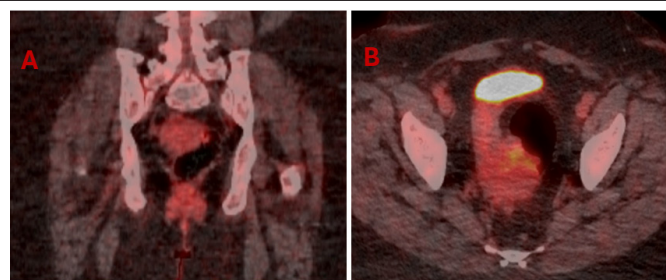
^{18}F FDG PET/CT shows low ^{18}F FDG uptake at the site of the preirectal soft tissue lesion.
